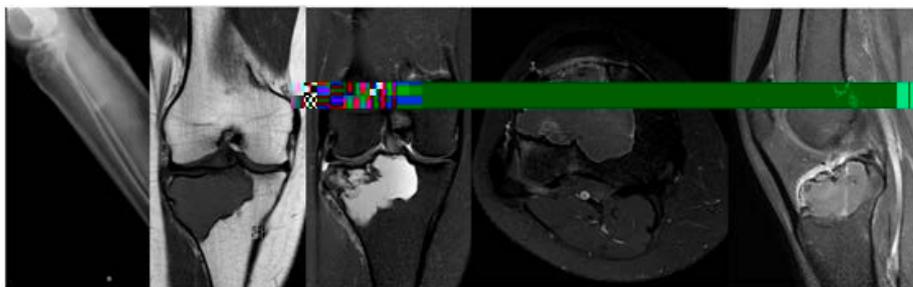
ABC, female, 33 years old, proximal tibia, type IA (radiography and MRI), fluid-fluid level 2/3, and small incomplete fracture. Score 3
